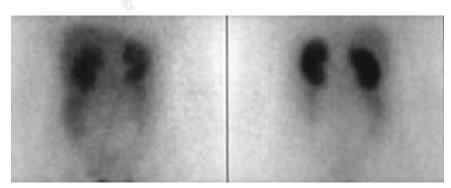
After DOTATOC treatment, ¹¹¹In-DOTATOC scintigram (anterior [left] and posterior [right] images) of abdomen revealed no enhancement in pancreas region or in liver. MRI finding was complete remission.
